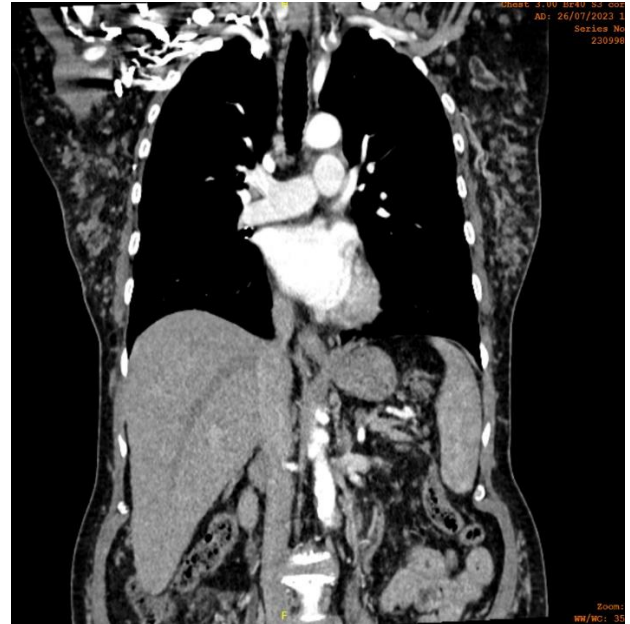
CT coronal demonstrating intraabdominal and subcutaneous lesions.
